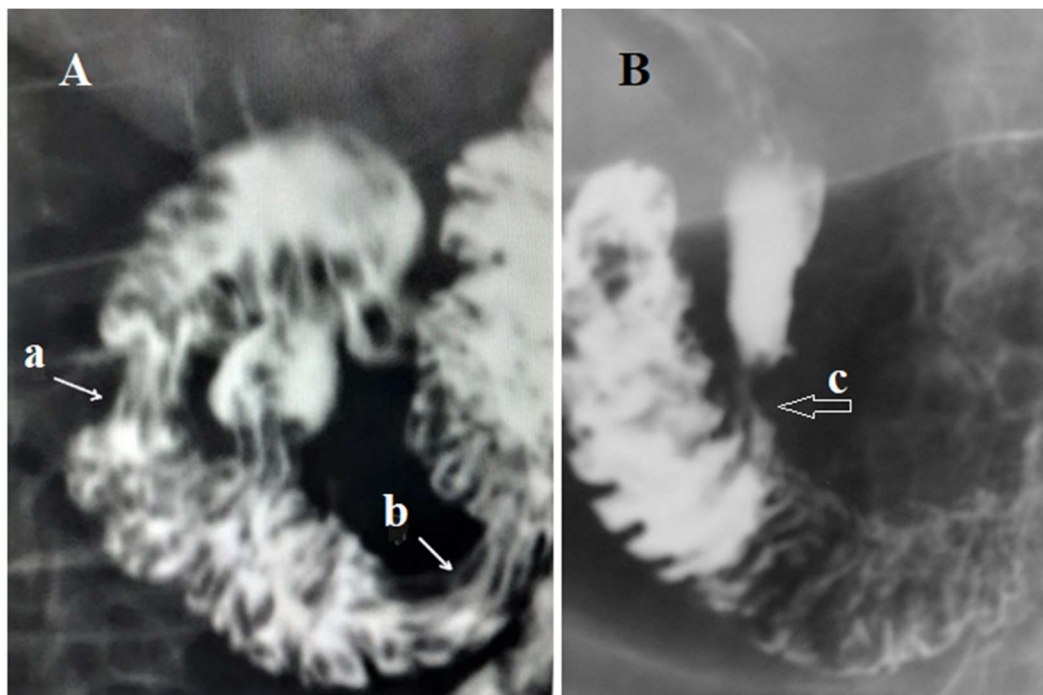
Radiographs of the duodenum to demonstrate of the duodenal sphincters. A. The simultaneous contraction of the sphincters Kapandji (a) and Ochsner (b) leads to increased pressure, as evidenced by the presence of juxtapapillary duodenal diverticulum. B. During ERSP, the contracted sphincter of Oddi is determined (c).
